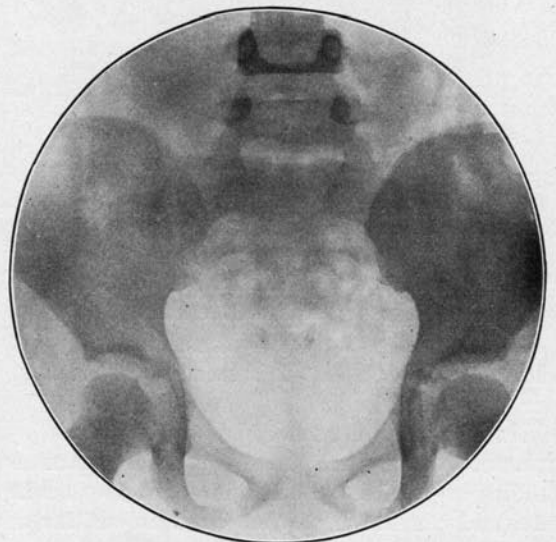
Florence B. Roentgenogram taken Feb. 7, 1915. Negative to vesical calculus.
